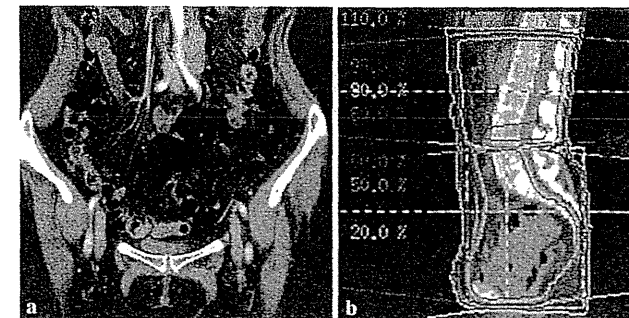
a Contrast-enhanced computed tomography image before the second external beam radiotherapy (EBRT) treatment. The arrow indicates the regrowing para-aortic lymph node. b Dose-distribution chart for the second EBRT plan
